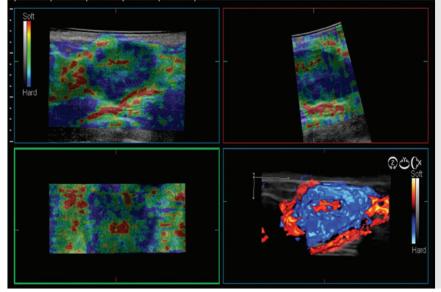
The three-dimensional (3D) strain elastogram of an invasive ductal cancer obtained on a Hitachi system (Hitachi Aloka America, Wallingford, CT) displayed as a 3D rendering. In addition to 3D rendering, 2D slices from the 3D data can be can be displayed in any plane. (Courtesy of Hitachi Aloka Medical, press release of February 7, 2011.)
